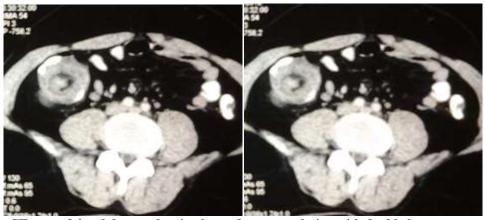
(a) & (b): CT scan of the abdomen showing hyperdense mass lesion with double lumen suggestive of ileocolic Intussusception
